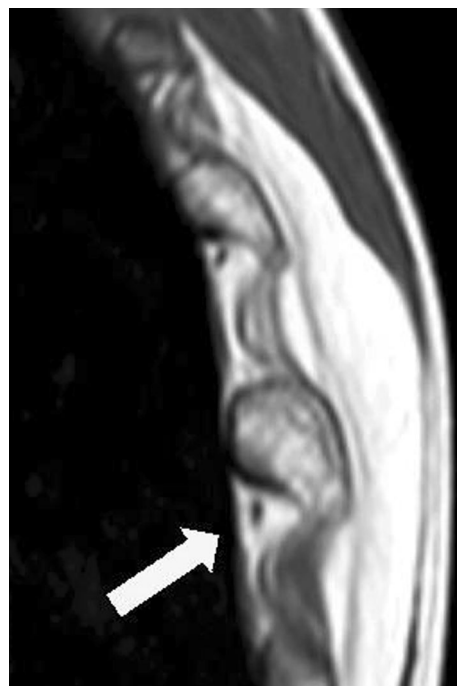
Sagittal T1-weighted view of the dorsal part of the chest wall including the normal sixth and hyperplastic seventh left rib, showing the intercostal blood vessels (light gray arrow), and absence of thickening of the accompanying nerve by interfascicular infiltration of adipose tissue
